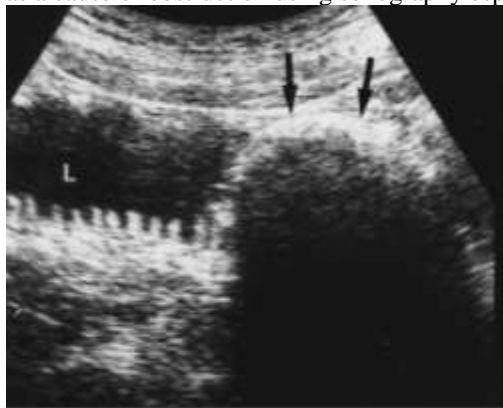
sonographic image showing intraluminal mass with a hyperechoic arc-like surface and a marked acoustic shadow.
